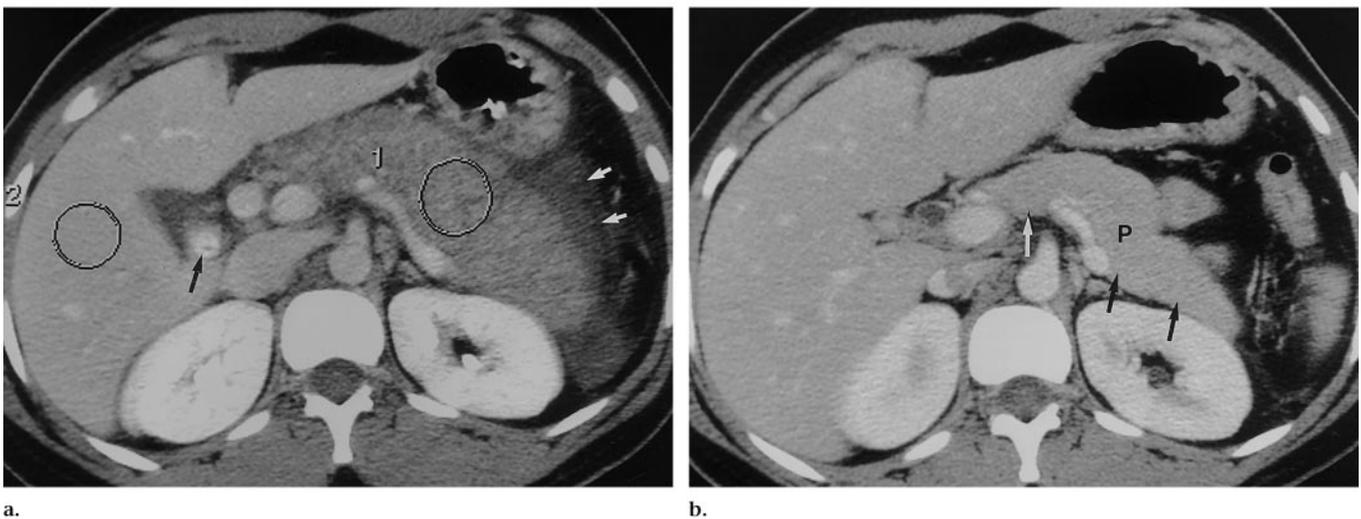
Gallstone-induced pancreatitis in a 27-year-old woman. (a) Transverse CT scan obtained with intravenous and oral contrast material reveals a large, edematous, homogeneously attenuating (73-HU) pancreas (*I*) and peripancreatic inflammatory changes (white arrows). Although the attenuation values are low, there is no pancreatic necrosis. Calcified gallstones are seen in gallbladder (black arrow). 2 = liver (140 HU). (b) Follow-up transverse CT scan obtained 7 days later reveals total resolution, with a normal pancreas (*P*, arrows) with CT number of 104 HU.
